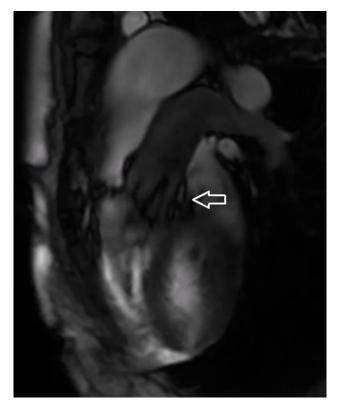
Cardiac MRI. White arrow: Thick muscle bundles in the pulmonary infundibulum conditioning a severe obstruction during systole.
